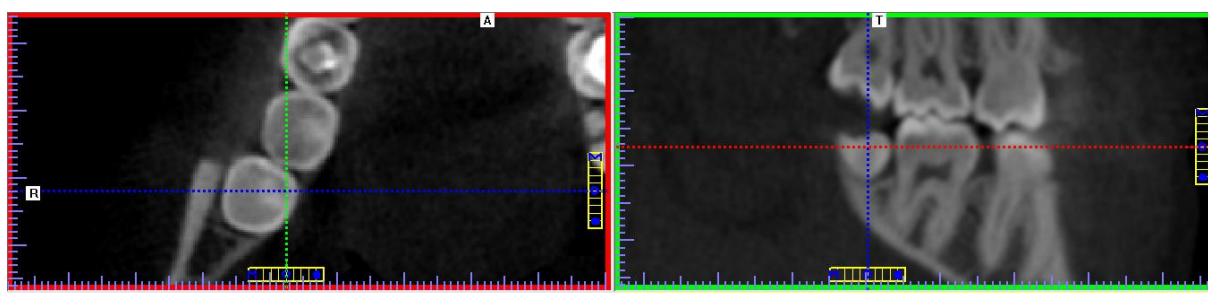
CBCT image of distal caries in tooth 47 (axial and sagittal sections)
